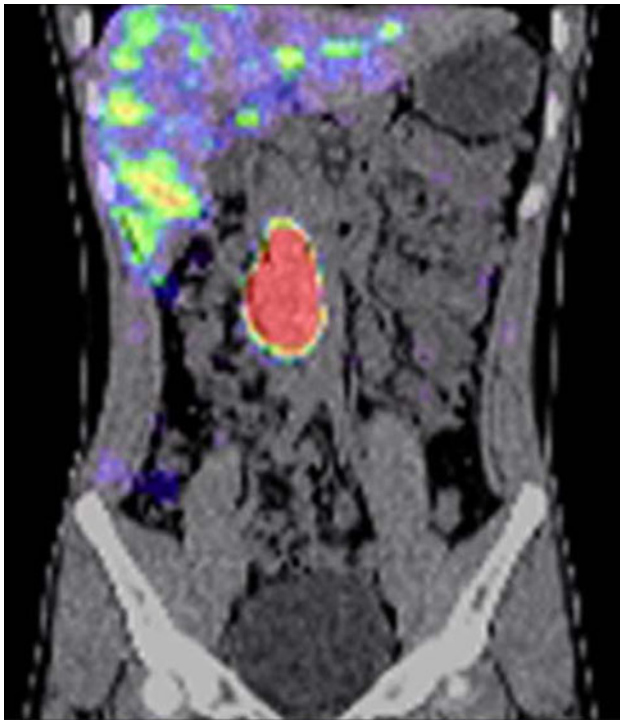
Single photon emission computed tomography (SPECT) (^{123}I -MIBG scintigraphy and computed tomography) revealed a tumor at the *right* renal hilum
